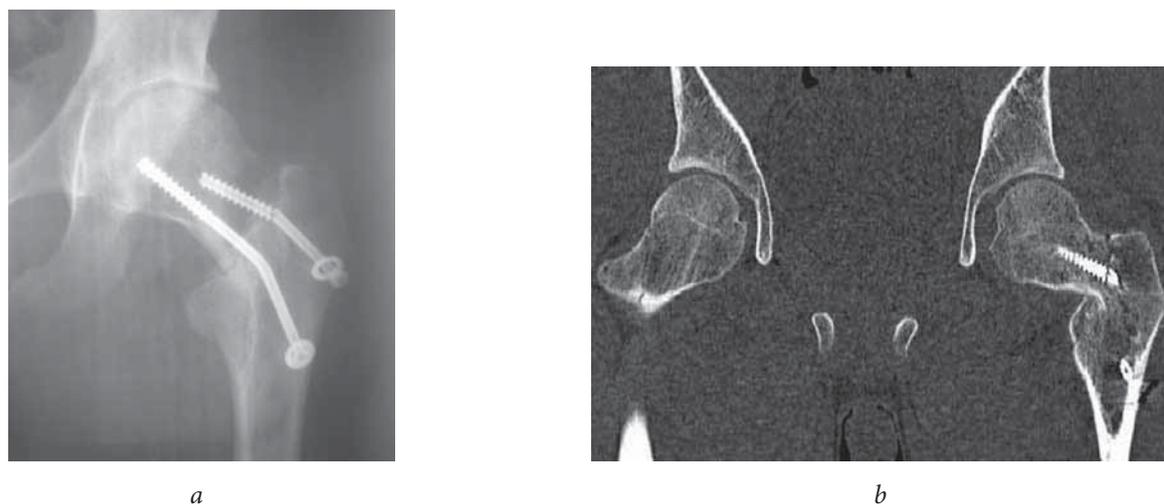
Patient M., 14 years old: *a, b* — radiograph and CT image of hip joints 11 months after repeated fracture of the femoral neck with fragments displacement and hardware destabilization: the solution of continuity of the femoral neck in the basicervical zone with the fracture of one cannulated screw and deformity of the other, the absence of trophic disorders in the femoral epiphysis
